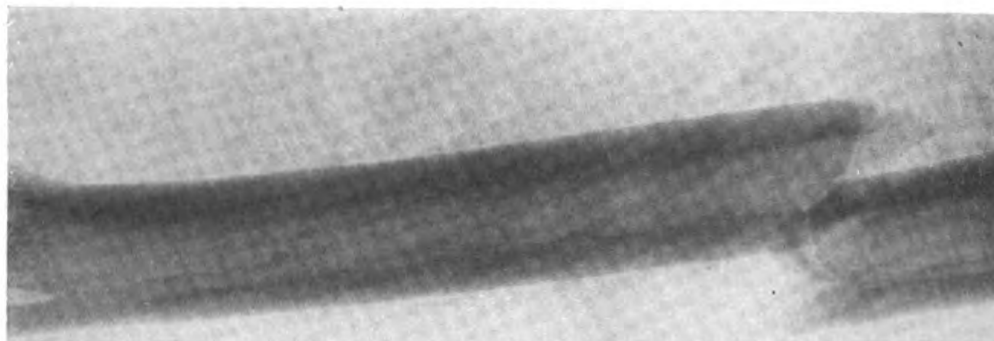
Case 4. Preoperative anterior-posterior x-ray.
